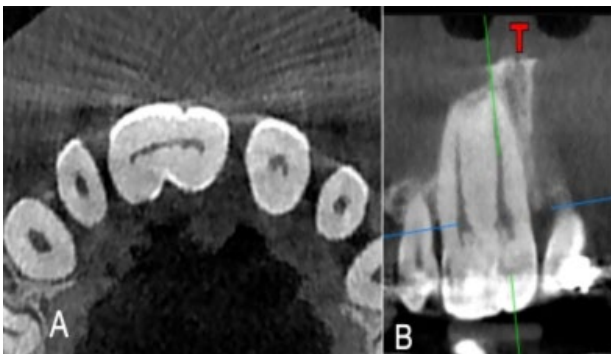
A) Axial section of CBCT shows the connection between the pulp chambers. B) Coronal section of CBCT shows the fusion of the roots and root canal separation.
